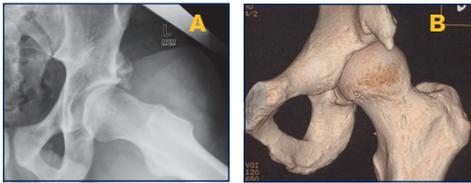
(2A) Frog leg lateral radiograph and (2B) 3D CT reconstruction demonstrate extensive heterotopic ossification in the region of the AIIS and a herniation pit in the anterior head-neck junction; a prime example of subspine impingement.
